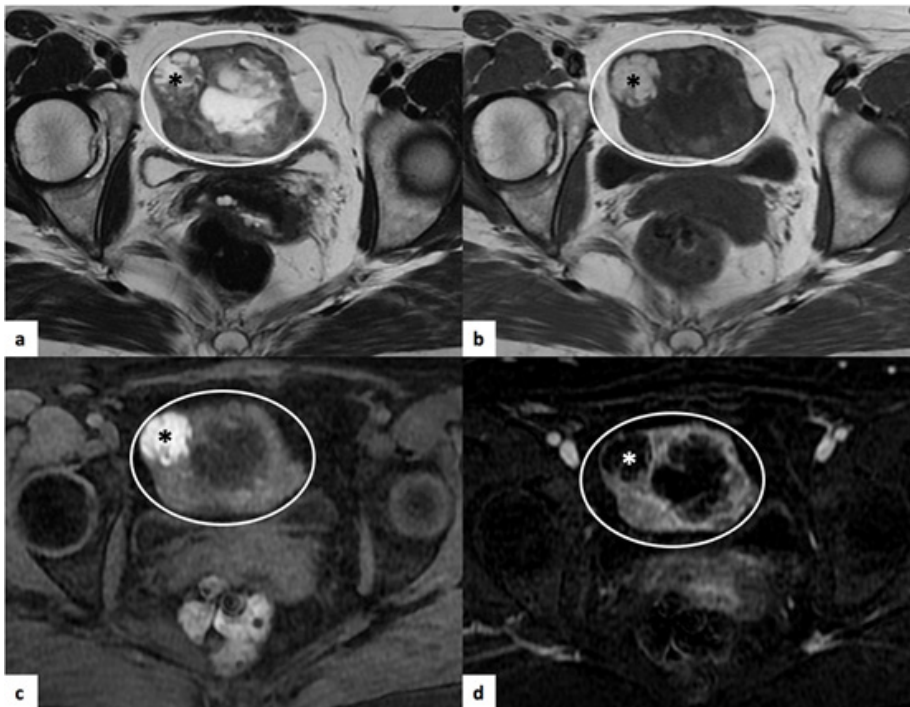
Struma ovarii of the right ovary. Pelvic MRI of a 46-year-old woman. (a) Axial T2-weighted image where there is a large lesion with mixed characteristics (circle), with heterogeneous solid and cystic components. (b) Axial T1-weighted image, where a spontaneously hyperintense area(*) is identified, which shows no loss of signal on the T1-weighted image with fat saturation (c), thus corresponding to haemorrhage. On the T1-weighted image after intravenous contrast T1 SPAIR (d) the solid component shows enhancement.
